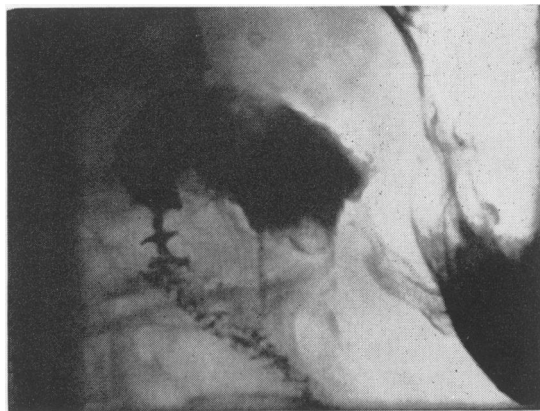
Barium meal radiograph (right anterior oblique view) showing megabulbus and stenosis of the second part of the duodenum.
